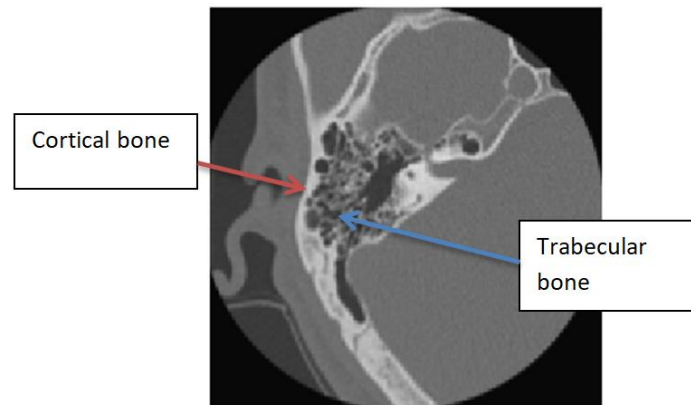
CT image of the temporal bone with the selection of cortical and trabecular bone [5]
